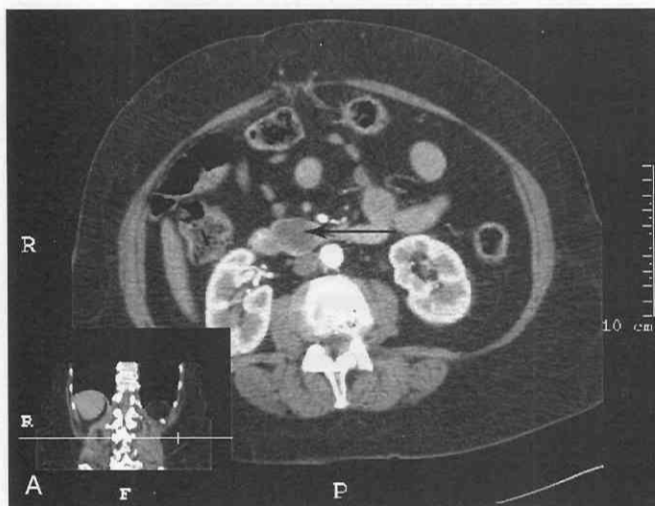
A, Small pseudocyst in the uncinate portion of the pancreas (arrow), on a CT scan obtained on multislice scanner. B, Coronal reconstruction shows pseudocyst (P) in lower uncinate process. The dilated major (vertical arrow) and minor pancreatic ducts (horizontal arrow) are above the cyst, which is also medial to the second portion of the duodenum (curved arrow).
